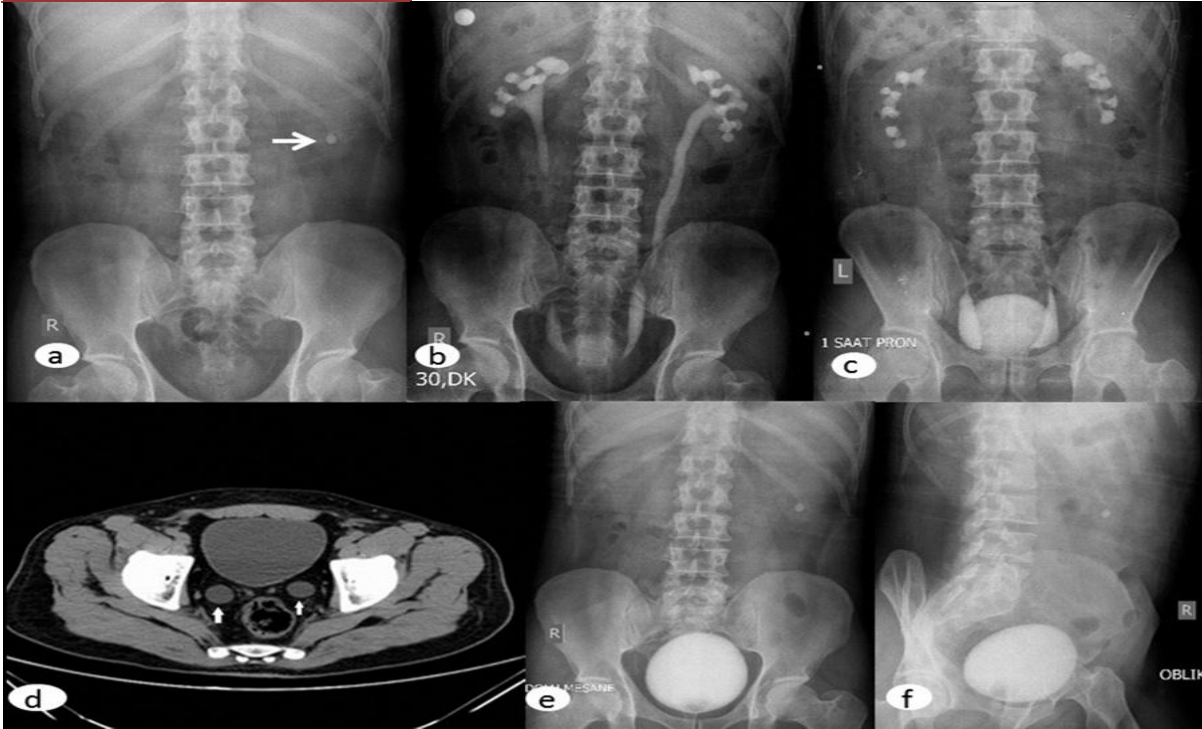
Radiological evaluations of patients with megaureter. a. Kidney ureter bladder x-ray, there is a 8 mm stone in the lower pole of left kidney (arrow). b. Intravenous urography of patient at the 30rd minutes. Dilated calices and ureters in figure. c. In prone position, dilated calices and ureter are still in figure, after 1 hour of intravenous urography. d Non-enhanced computed tomography. There are bilateral dilated distal ureters (arrows). Diameter of left ureter is 16 mm and right ureter is 18 mm. e. Voiding cystourethrogram of patient in anterior-posterior. f. There was no refluxing in oblique voiding cystourethrogram.
